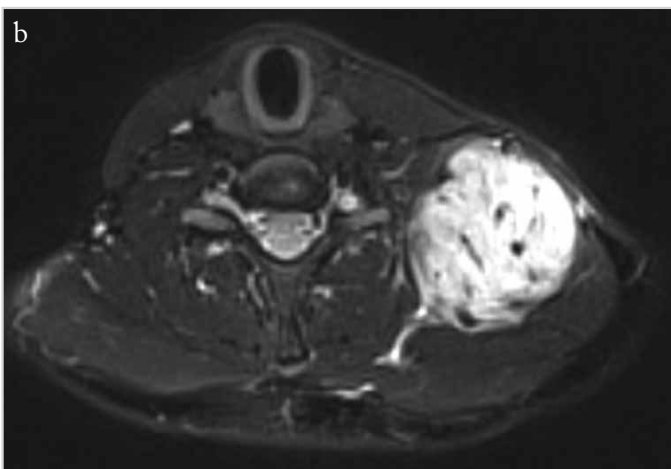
a, b. Magnetic resonance imaging showed a lobulated tumor in the left scalene muscles, which has (a) hypointense signal voiding on T1 coronal section (star indicates the tumor and arrow indicates the left scalene muscles) and (b) increased signal intensity on T2 axial section
